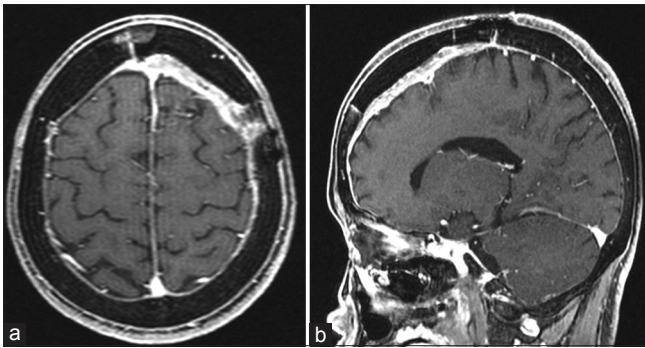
T1 contrast-enhanced post-operative magnetic resonance imaging scans on axial (a) and sagittal sections (b) respectively showing complete excision of the lesion
